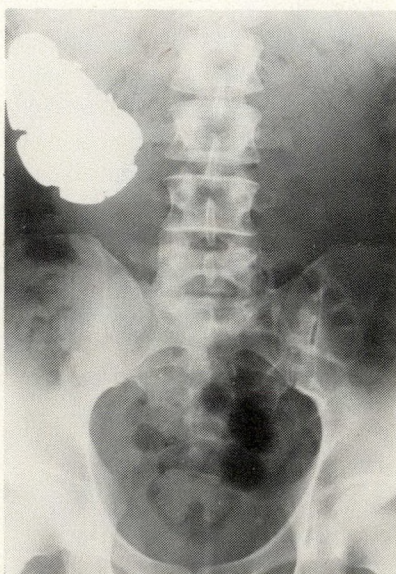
Supine plain film showing large, multisurfaced, radiopaque mass in right upper quadrant.
